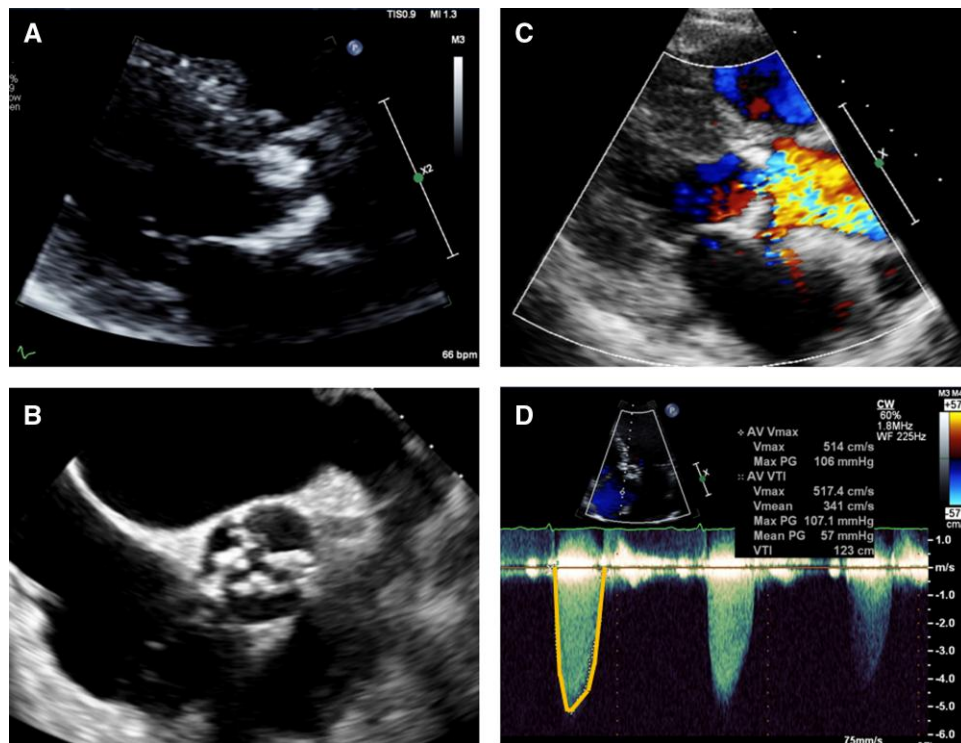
Echocardiographic findings in severe aortic stenosis. Two-dimensional parasternal long- and short-axis imaging demonstrating severe aortic valve leaflet and annular calcification (A, B). Colour Doppler shows turbulent flow (C) with a peak aortic valve velocity >5 m/s on continuous wave Doppler evaluation (D).
